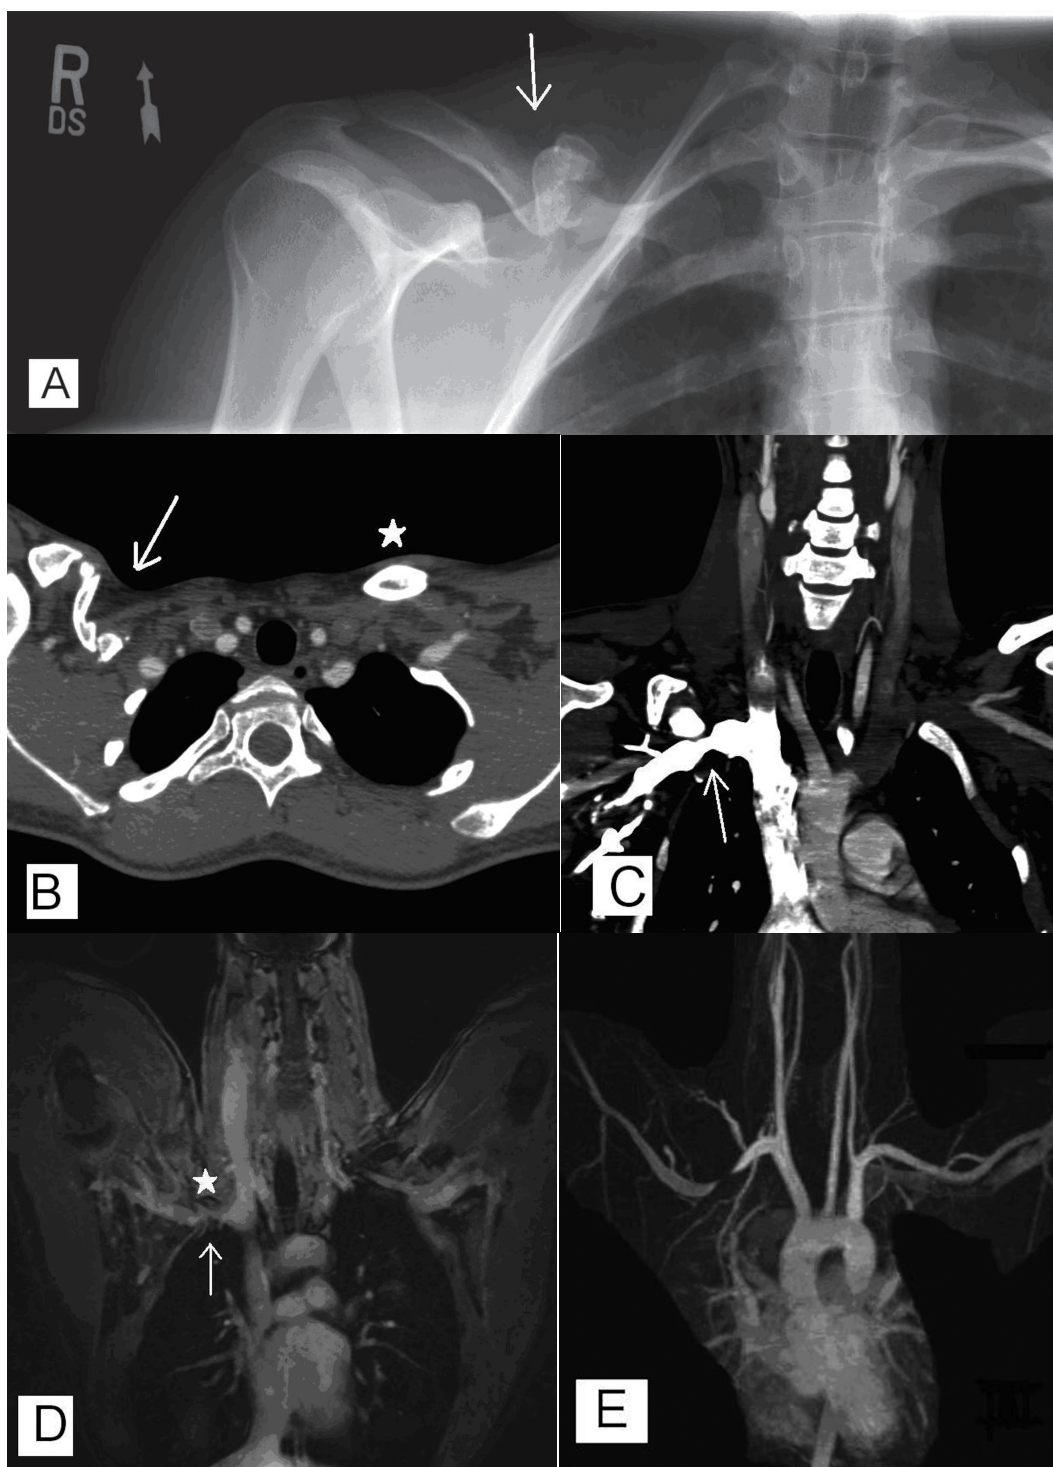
(A) X-ray of the right clavicle shows a deformity in the midshaft (arrow) with evidence of pseudoarticulation at each end. The lateral segment is subluxed superiorly and demonstrates a serpentine course. (B) Axial CT with contrast of the thorax shows the U-shaped pseudoarthrosis of the right clavicle (arrow) displaced posteriorly and compressing the underlying structures. The usual anterior position of the contralateral normal clavicle (star) is visualized for comparison. (C) Coronal sequences of CT angiography of the neck and thorax shows narrowing of the right subclavian vein (arrow). Superior to the vein are two fragments of the pseudoarthrosis showing the pseudoarticulation between the two. (D) Coronal sequences of magnetic resonance venography of the neck and thorax with patient's arms elevated demonstrate the pseudoarthrosis (star) causing compression and narrowing of the right subclavian vein. (E) Coronal sequences of magnetic resonance angiography of the neck and thorax with patient's arms elevated show an hourglass-shaped narrowing of the right subclavian artery.
